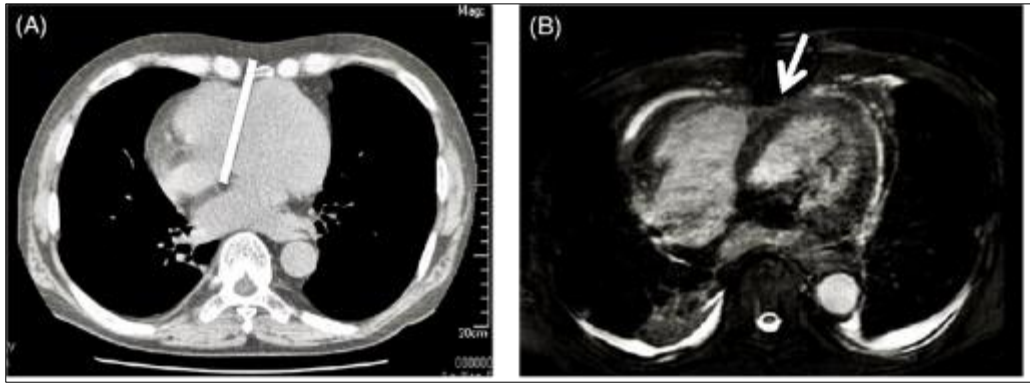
Computed tomography (CT) (A) and magnetic resonance imaging (MRI) (B) revealed counterclockwise rotation of the heart. Differences from the normal cardiac position comprise the right ventricle located directly over the right atrium, the interventricular septum located in an upright position, and the apex of the heart located in the mid-thorax. These findings indicated the presence of mesocardia. The white line and white arrow show the interventricular septum
